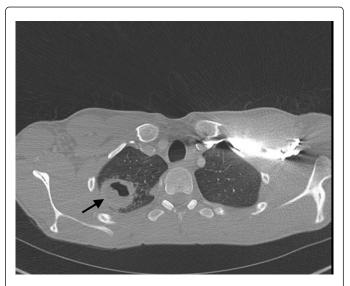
Axial chest CT without contrast with arrow showing a solitary thick walled cavitary lesion in the right upper lobe and adjacent pulmonary consolidation.
